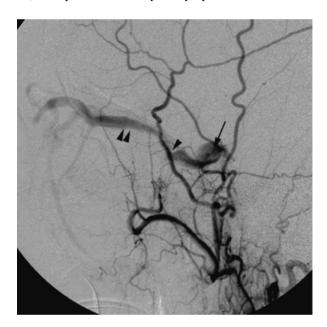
(a) Computed tomography angiogram (CTA) and (b) digital subtraction angiogram of ethmoidal DAVF showing the large dilated draining vein
